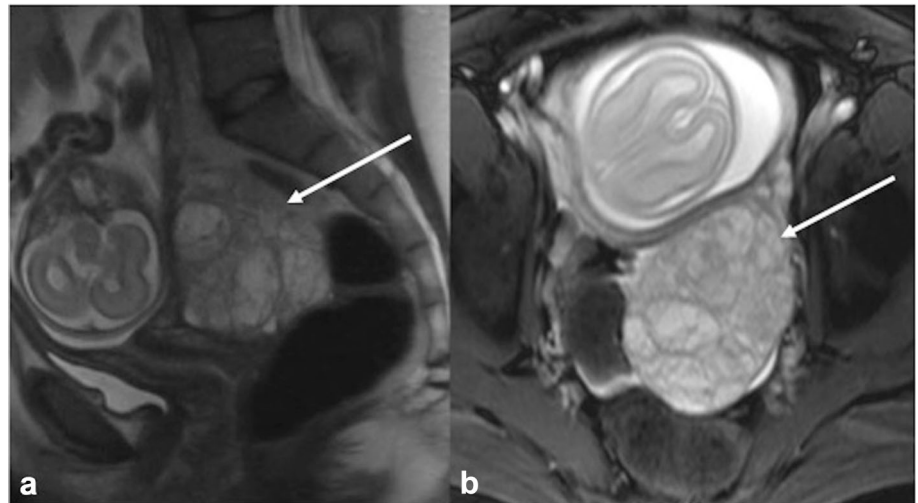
A 24-year-old woman, G2P1, at 23 weeks of gestation, with left adnexal mass incidentally discovered at first trimester ultrasound. a Sagittal T2 HASTE and b axial truFISP images demonstrate multicystic heterogeneous left ovarian mass and a gravid uterus. Pathology confirmed mixed tumor, 90% juvenile granulosa cell tumor, and 10% gonadoblastoma/dysgerminoma
